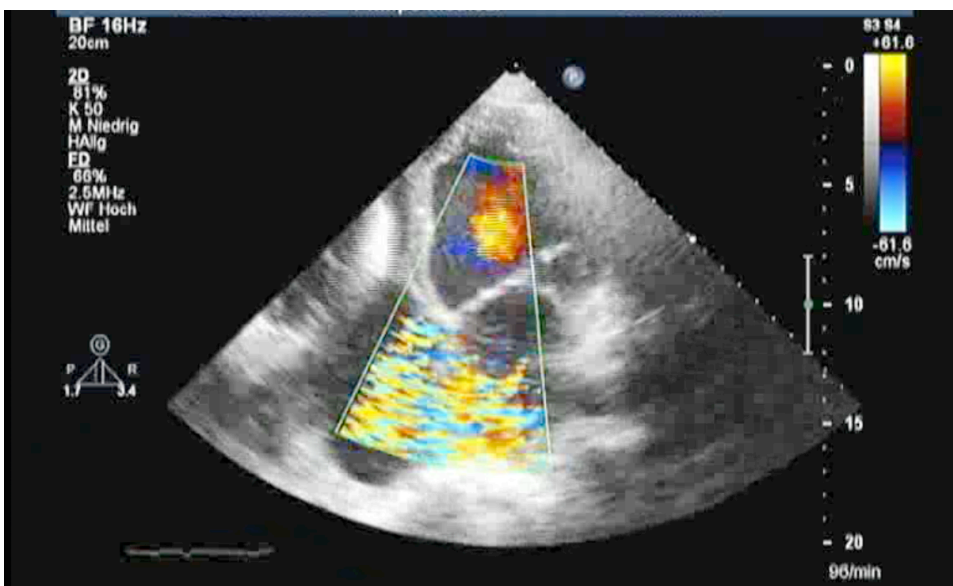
A Standard apical 4 chamber view
